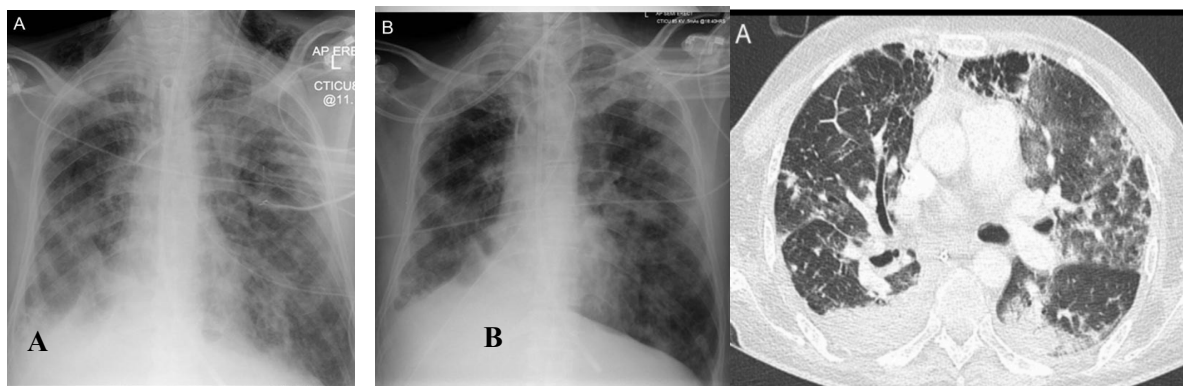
Chest radiograph of patient with ARDS shows bilateral infiltrates. There is bilateral consolidation and a right pleural effusion. B: Chest radiograph of the same patient shows persistent bilateral infiltrates after 7 days⁸⁵
